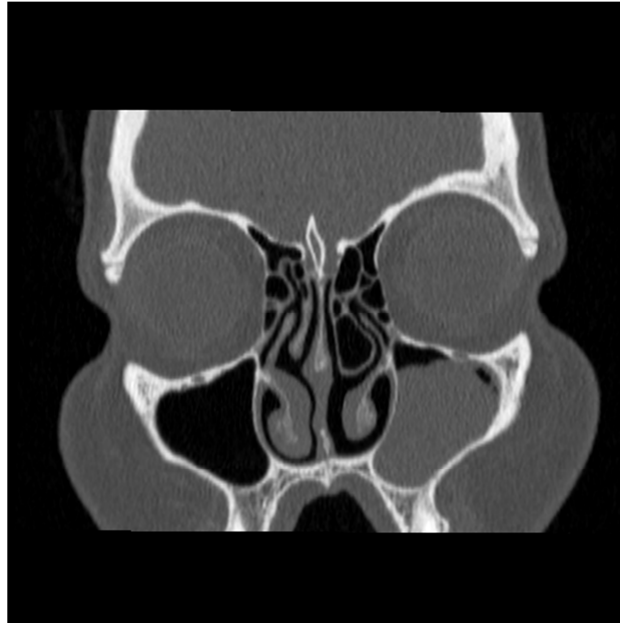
Coronal Paranasal Sinus Computed Tomography View for Left Unilateral Concha Bullosa
